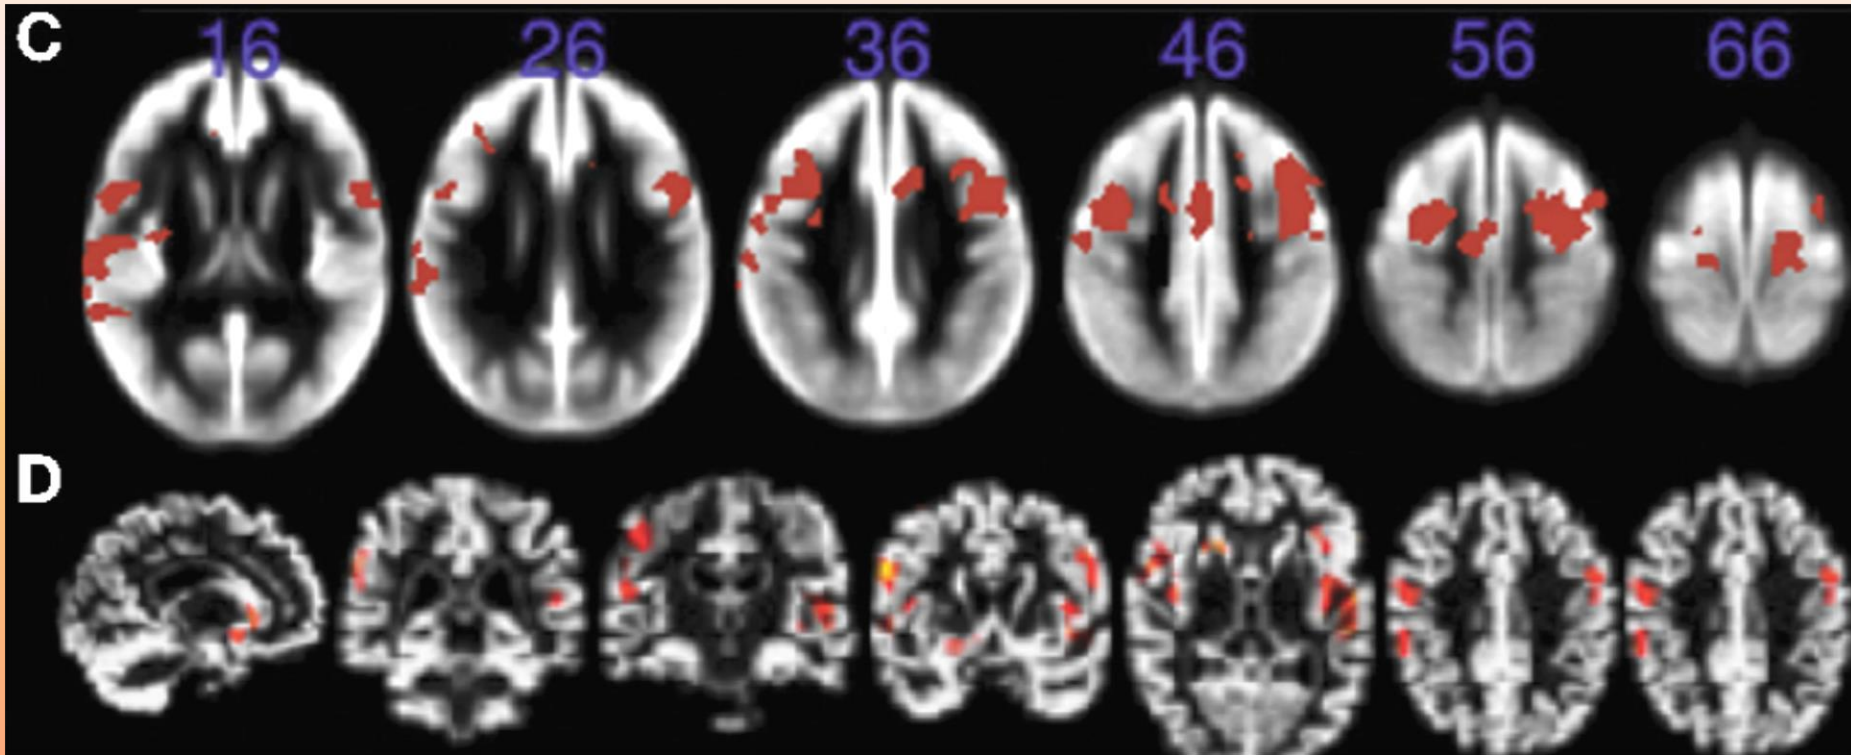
Structural MRI studies showing positive relationships with brain volume and fitness.
